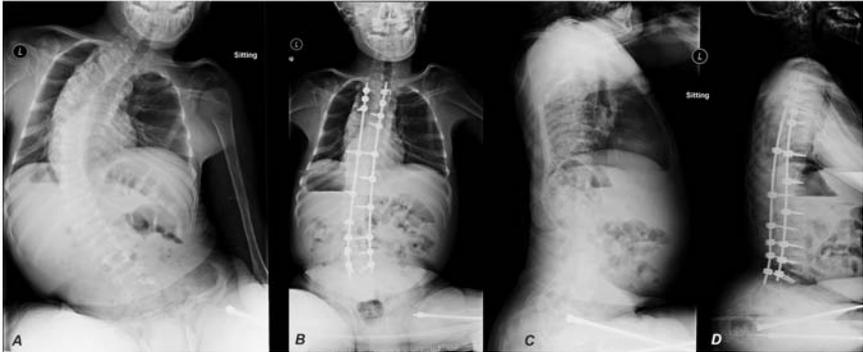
Radiographs of a patient with OI type IV who presented at 4 years of age with a 20° left thoracic scoliosis and progressed to 97° by 15 years of age (A,C), when he underwent T2-L4 instrumented posterior spinal fusion (B,D).
